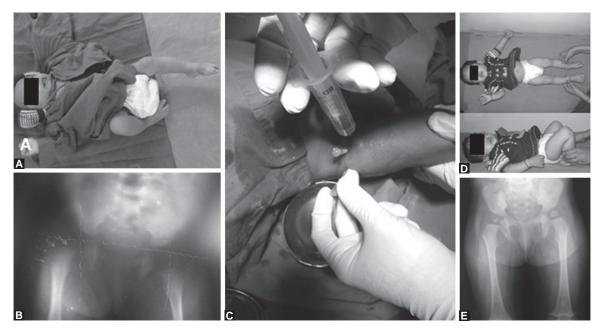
A, Clinical photograph of a 25-day-old neonate with septic arthritis right hip. There is fixed flexion deformity at right hip and baby refuses to move the right lower limb. B, An X-ray shows right hip dislocation, which is due to inflamed synovium pushing the head outside the acetabulum. C, Joint wash of the right hip was done by mini-invasive technique using 16 G needles through multiple ports. This was followed by course of intravenous and then oral antibiotics. D, Clinical photographs showing one and half year follow-up with full range of movement at right hip joint and no limb length discrepancy. E, X-ray done at 15 months suggests growth is getting affected and small-sized epiphysis of right hip
